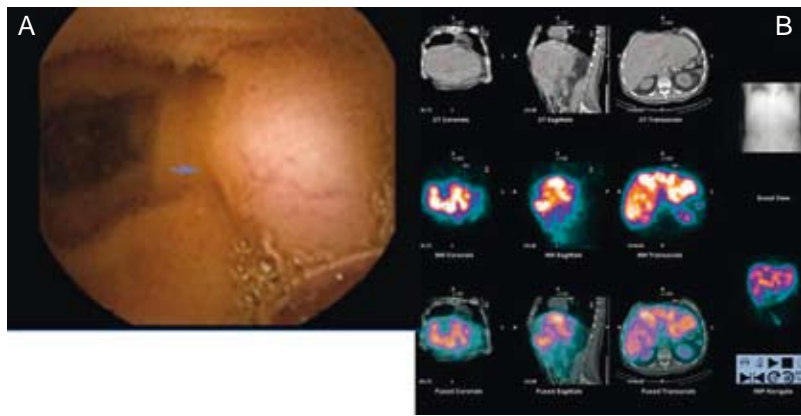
A) Video capsule endoscopy. B) SPECT-CT with ^{111}In -DTPA-D-Phe-octreotide.
